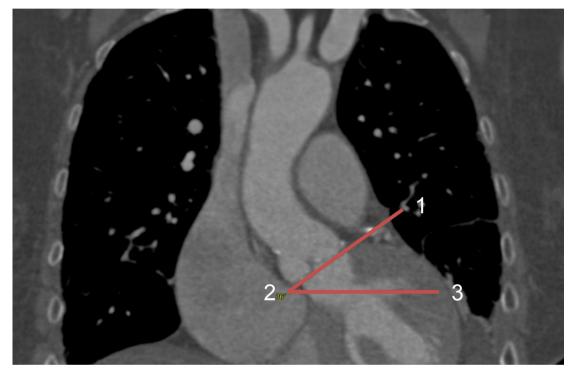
Figure CTA-8: A ortic root angulation measurement on the standard coronal image. Use the angle tool beginning at point 1, with point 2 on the lower right of the patient, and the final point on the lower left of the patient. The first line, between points 1 and 2 should be along the aortic annulus. The second line, between points 2 and 3, should be horizontal in the coronal image, which represents the axial plane of the patient.
